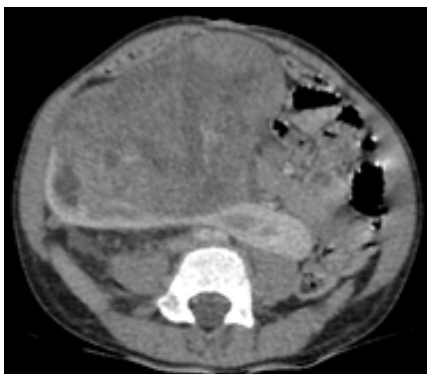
Contrast enhanced CT in the axial plane shows fusion of the kidneys represented by a band of renal parenchyma or isthmus across the midline. There is a large, heterogeneously enhancing mass lesion arising from the right side, extending anteriorly and across the midline.
